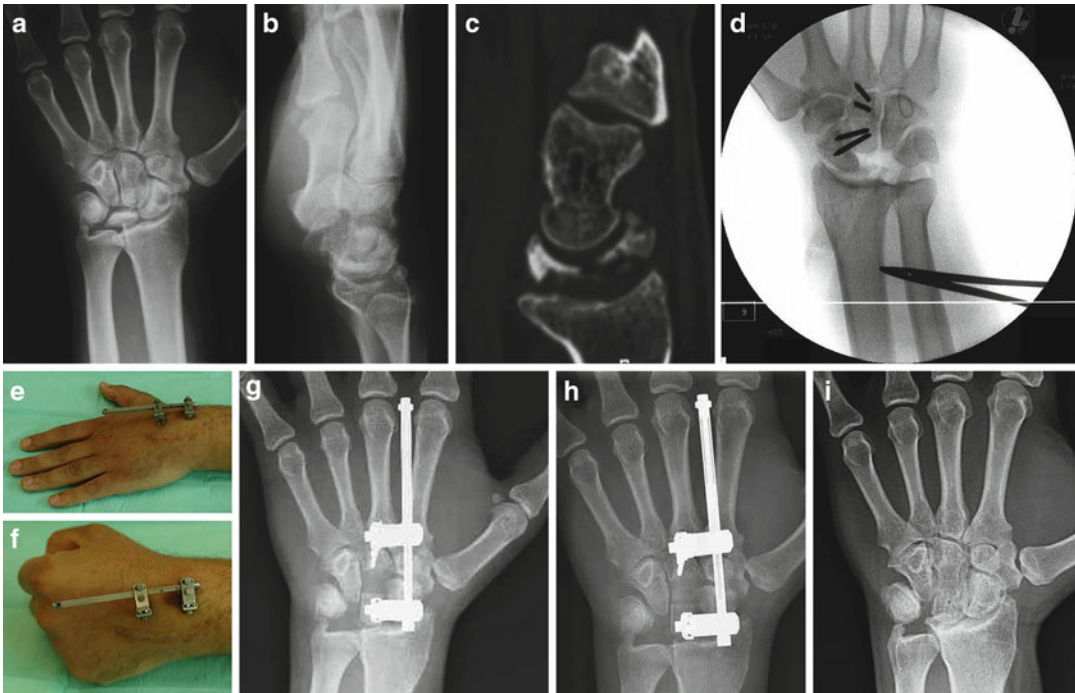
Graner–Wilhelm progressive lengthening of the capitate after lunarectomy for the treatment of a patient with stage III-B Kienböck’s disease of the left wrist. (a, b) Preoperative X-rays. Note the existence of a lunate distal medial facet for articulation with the hamate (Viegas type II lunate). (c) Preoperative CT scan, demonstrating fragmentation of the necrotic lunate. (d) After resection of the lunate by dorsal approach, 39/2 mm external minifixation half pins are implanted in the head and corpus of the capitate. An osteotomy was then performed at the capitate’s corpus, distal to the capitate neck. (e–g) Progressive distraction is applied after 7 days without wrist/hand immobilisation. (h, i) X-rays 32 days 46 days
